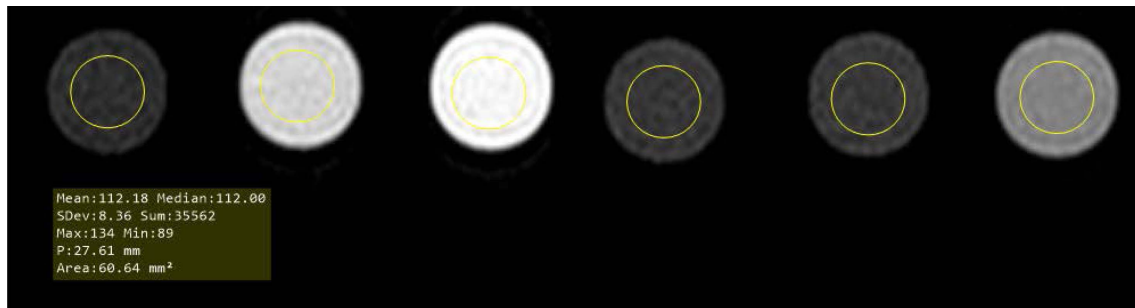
(Color online) Axial longitudinal relaxation (T1)-weighted MR images of contrast media (left to right) water, iodinated contrast media, pineapple juice, apple juice, orange juice, and grape juice, and mean and standard deviation measurements using the region-of-interest (ROI) function of the MicroDicom Viewer.
